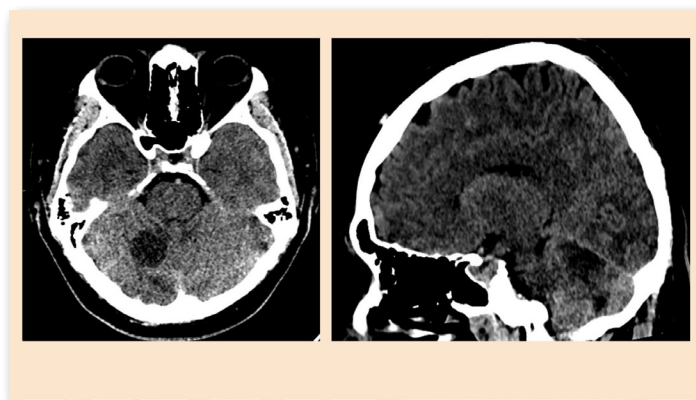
CT non-contrast: moderate-sized subacute infarction in the right cerebellar hemisphere involving the right superior cerebellar artery territory.
